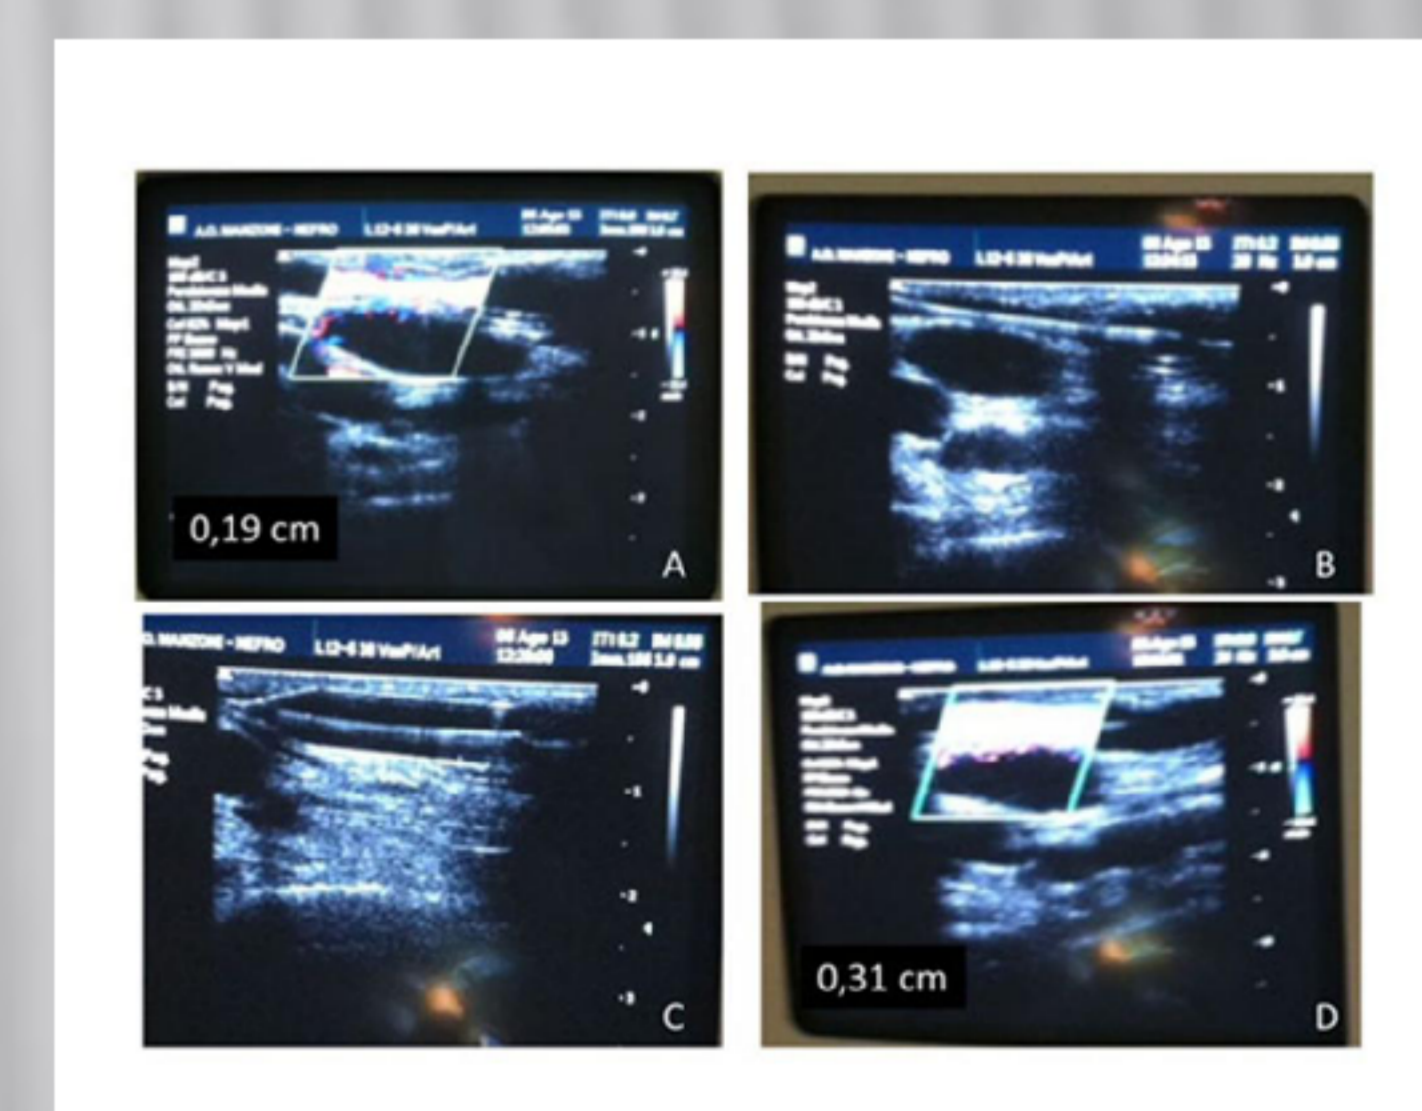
PTA performed under ultrasound guidance
